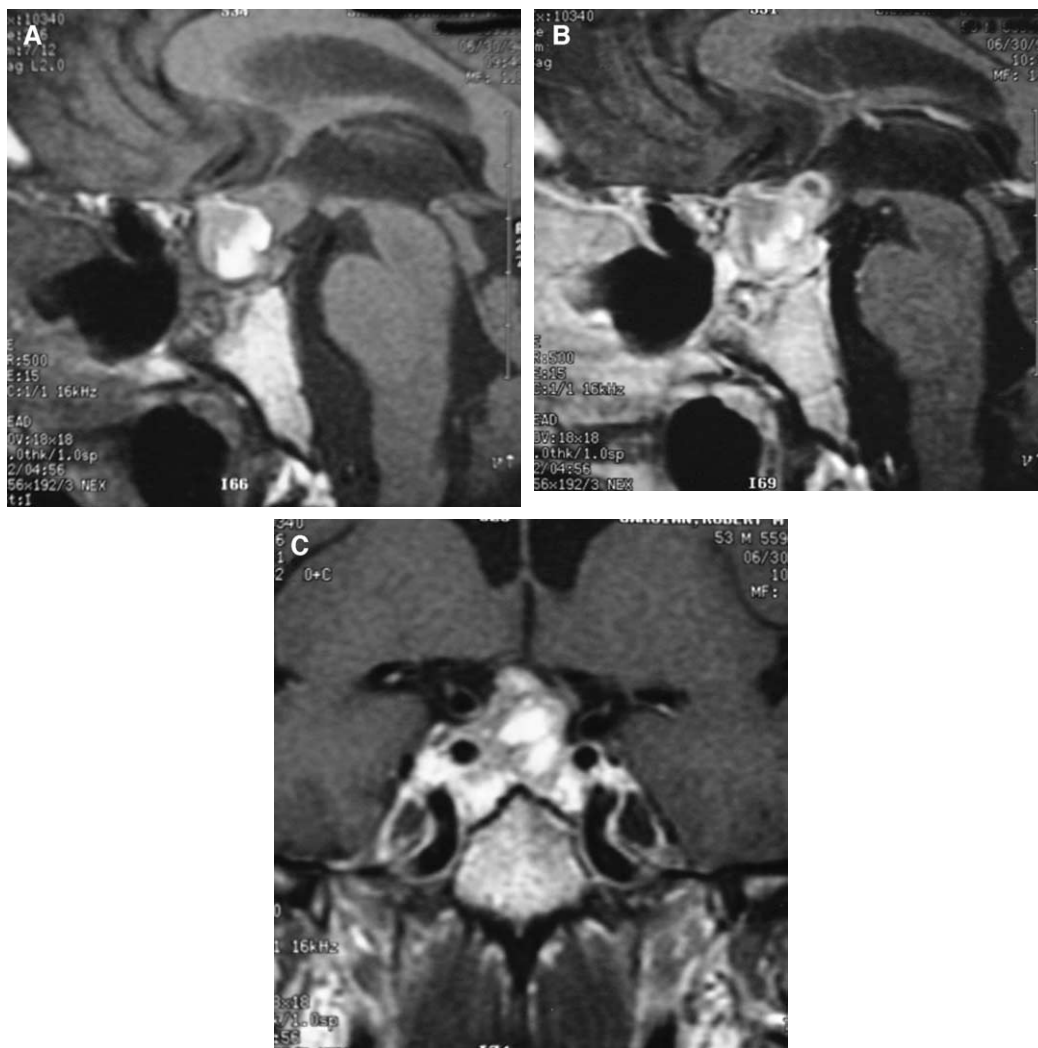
Hemangiopericytoma. (A) Sagittal T1-weighted image shows a sellar suprasellar mass with mixed signal intensity. Areas of hyperintensity are probably caused by focal hemorrhage. (B) Sagittal postcontrast T1-weighted image demonstrates irregular enhancement of the mass lesion. (C) Coronal postcontrast T1-weighted image demonstrates irregular enhancement of the mass with suprasellar extension and right parasellar extension into the cavernous sinus. Note that the mass surrounds the right internal carotid artery completely.
